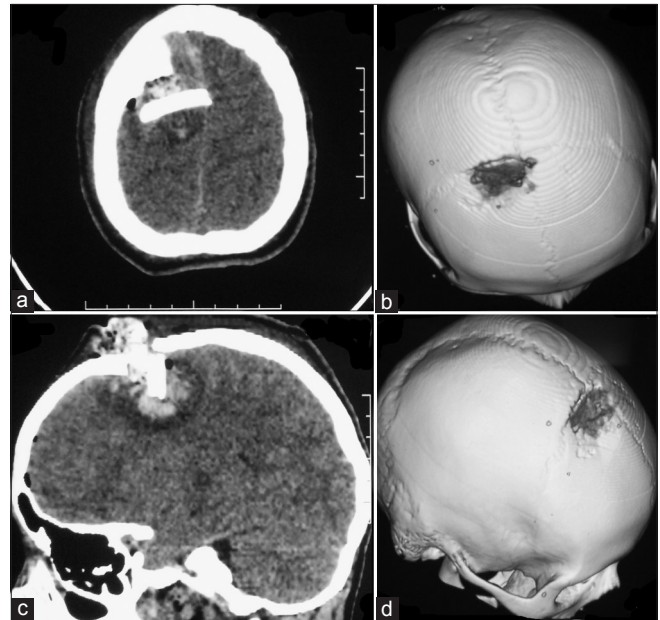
CT brain (a) axial (c) sagittal views show the compression of the SSS and presence of a FB. (b and d) 3D reconstruction images showing the site of skull defect
